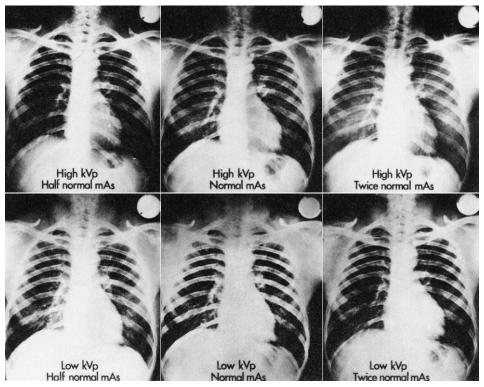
Chest radiographs demonstrating two advantages of high-voltage technique: greater latitude and margin for error. (Courtesy Carestream Co.)
